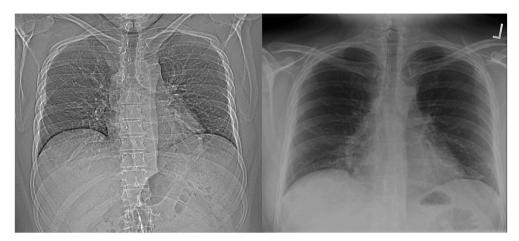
Scout film of chest CT after chemotherapy demonstrating low lung volumes compared to prior chest x-ray.
